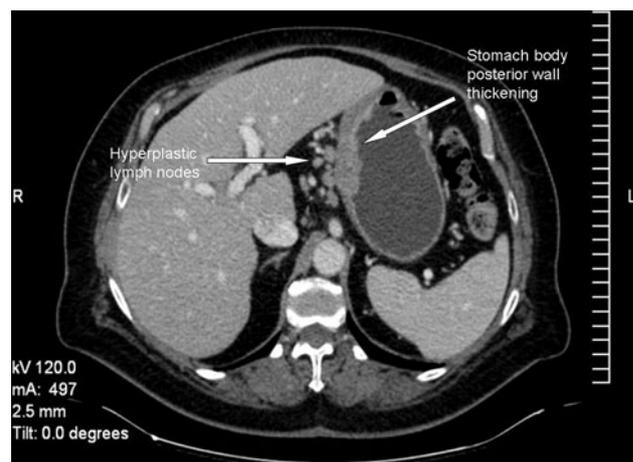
CT scan of irregular thickening of the posterior wall of the stomach body, associated with hyperplastic lymph nodes along the lesser curvature of the stomach, liver hilum and celiac, portacaval and inter-aorto-caval regions, as well as splenomegaly
